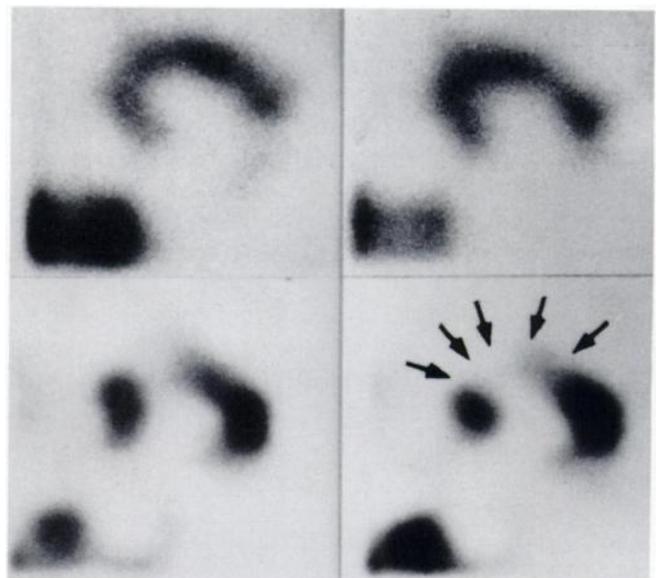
Single-photon emission computed tomograms in the short-axis view from a patient with anterior MI obtained during the first (Patient II-8, upper images) and second (Patient III-2, lower images) ^{111}In -antimyosin scintigraphic studies. Note the loss of radioactivity at the center of the lesion that had been positive in the initial study (arrows).
